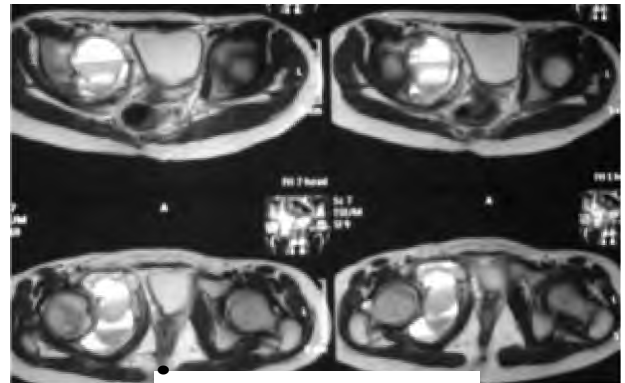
Axial T2W MR images showing the lesion cystic appearance with multiple fluid-fluid levels and the intra pelvic extension displacing the urinary bladder, acetabular & ischial involvement.
